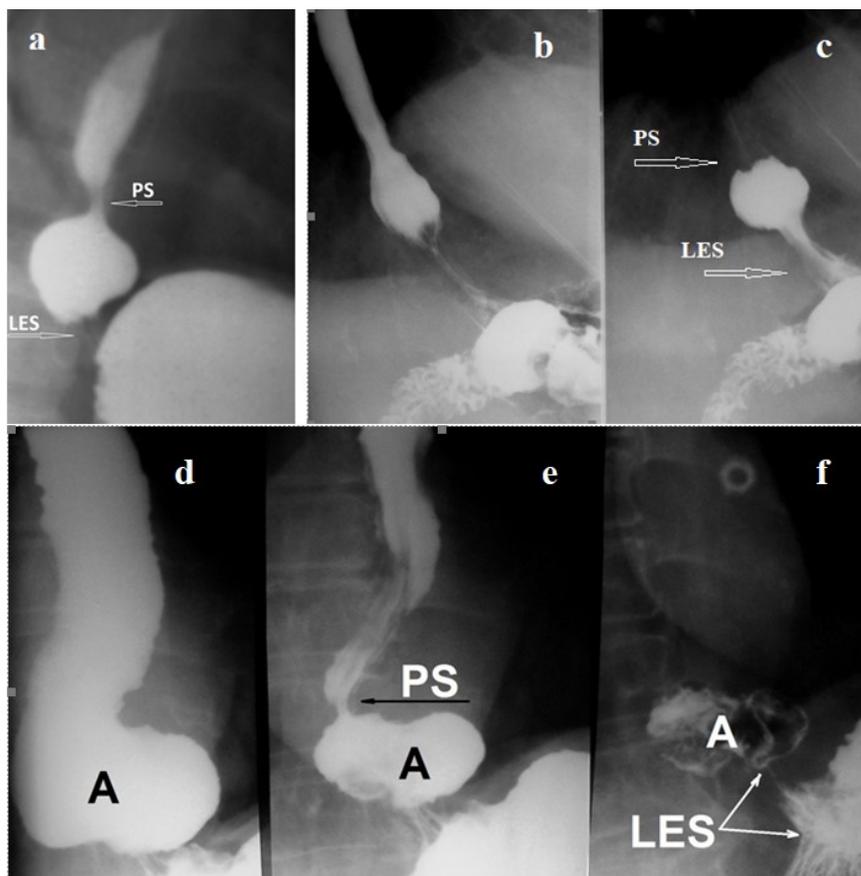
Radiographs of GEJ during compression of the abdomen. (a) A 5-year old child with symptoms of GERD. The compression of the abdomen during the swallowing of barium caused a contraction of the LES. The last peristaltic wave formed a closed chamber (phrenic ampulla), which was closed proximally by a proximal sphincter (PS). (b-c) The phrenic ampulla during contraction creates high pressure to open the LES. (d-f) A series of radiographs of the elderly patient with GERD (d) During abdominal compression, LES contracted and barium filled the wide ampulla and esophagus. (e) After the end of the abdominal compression, ampulla (A) injects a barium into the stomach. This has been made possible thanks to a contraction of PS. (f) The shortening of LES is due to the incompetence of the abdominal part of LES that appears as angular deformity (opening) of the cardia.
